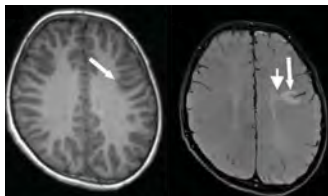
Routine axial MRI (left) appears normal, whereas FLAIR (right) reveals a subtle FCD (photo: Kusama et al., *Neurology: Clinical Practice* 2021, CC BY 4.0).
